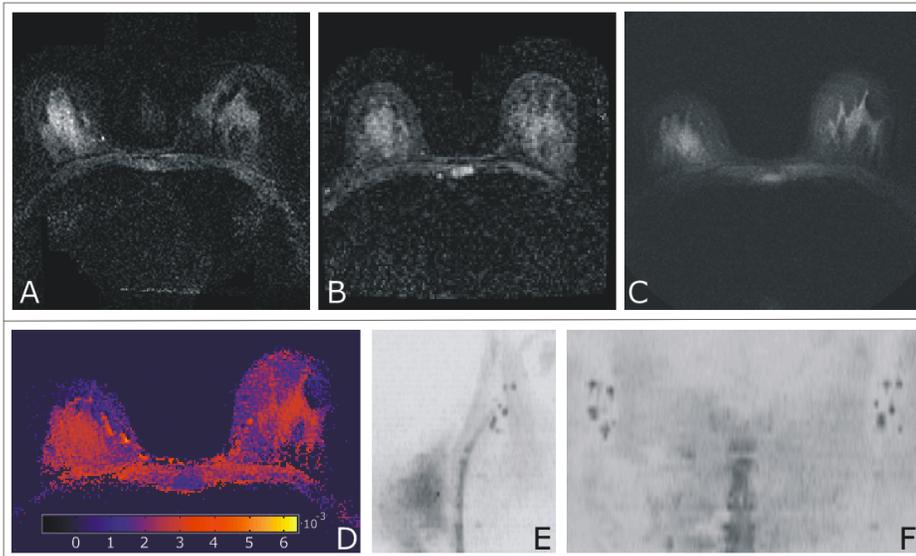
High-resolution DWI of the breast at 1.5T; A. 256x256 ASSET-DW-EPI, severely distorted, despite parallel imaging; B. 128x128 ASSET-DW-EPI; C. 256x256 SNAILS-DWI. D. ADC map from C. E+F. High-resolution SNAILS data set allows multiplanar reformats, clearly showing axillary lymph nodes on both unilateral sagittal MIP (E) and coronal chest-wall MIP (F).
